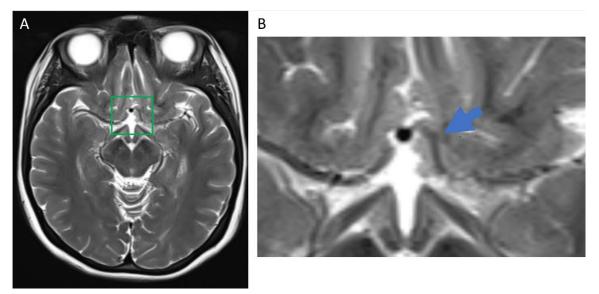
A 23-year-old female patient with infundibular dilatation of the A1 Segment of the Anterior Cerebral Artery Findings: A1 segment of the left anterior cerebral artery (ACA) with suspected outpouching lesion (blue arrow). Technique: Cerebral MRI, T2-WI sequence, axial plane (1A) with magnification (1B).
